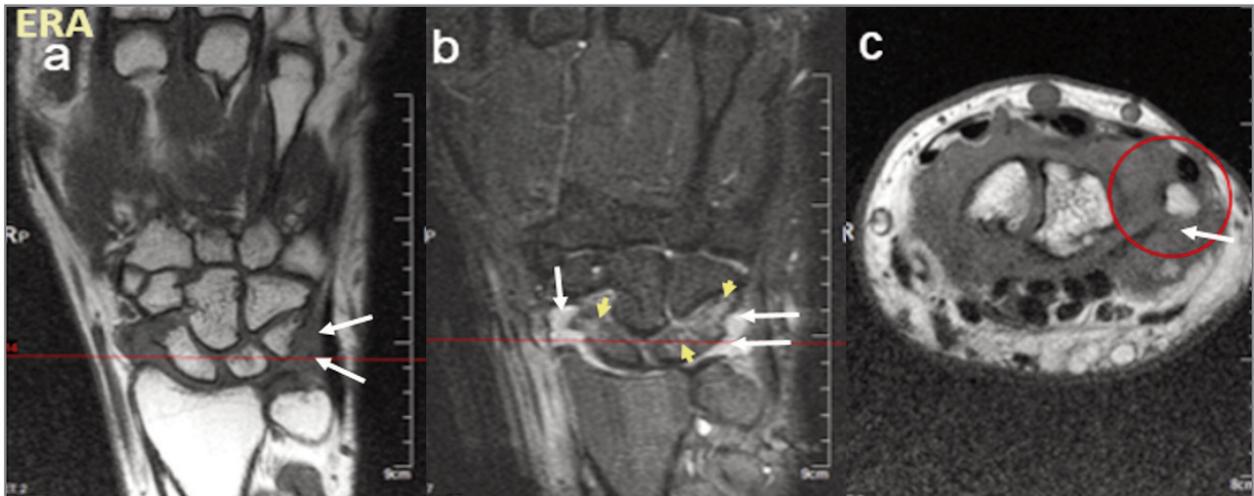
Hand-wrist MRI Coronal T1 and STIR in an early rheumatoid arthritis (ERA) patient. First Carpal line lesions in a 35 year-old man diagnosed with ERA. White arrows show synovitis; yellow arrows show bone marrow edema (osteitis). A) T1 sequence synovitis in triquetrum and prestyloid-triquetral recess is seen hypointense (dark gray signal) (white arrow). B) STIR sequence synovitis is seen hyperintense (bright white signal) in triquetrum and prestyloid-triquetral joint recess and radio-scaphoid-trapezoid joint (white arrows); BME/osteitis is seen as hyperintense signal in triquetrum, lunare and scaphoid bones (yellow arrow heads); C) T1 axial slice (corresponding to the red line level in the coronal plane), joint effusion synovitis triquetrum is seen hypointense (white arrow)
